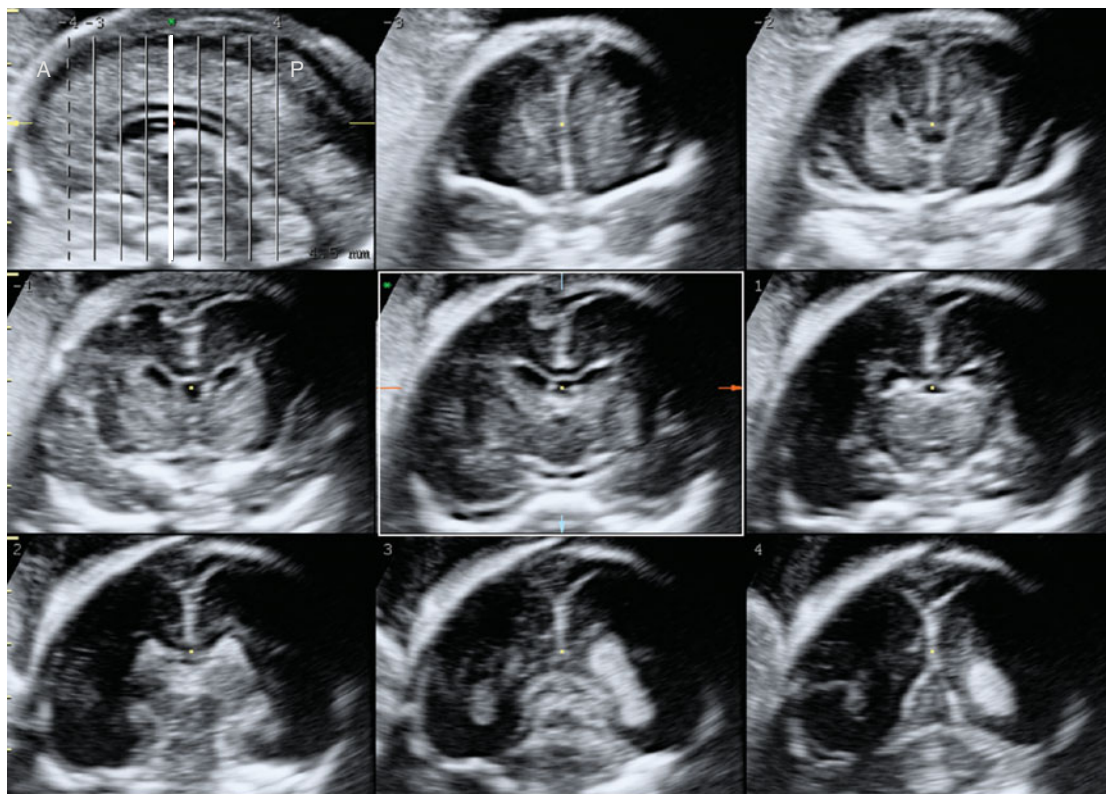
Tomographic ultrasound image obtained on a normal fetal brain at 22 weeks' gestation demonstrating successive coronal sections displayed from anterior (A) to posterior (P). The coronal planes correspond to the planes that are marked crossing the brain on the sagittal image. The slice interval is 4.5 mm and the "marker dot" is seen in the midline on the cavum septi pellucidi.
